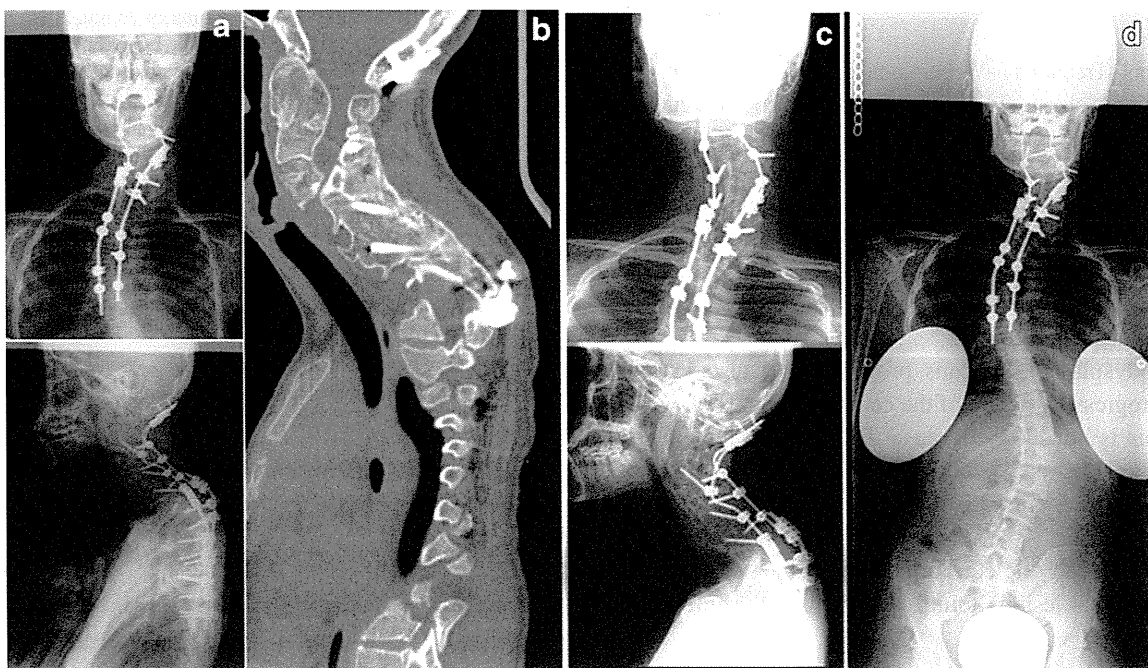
Plain radiographs of the cervical spine taken at immediately after operation (a). Spine was fused from occiput to T7 level. An abnormally protruded bone was excised and iliac bone was grafted
